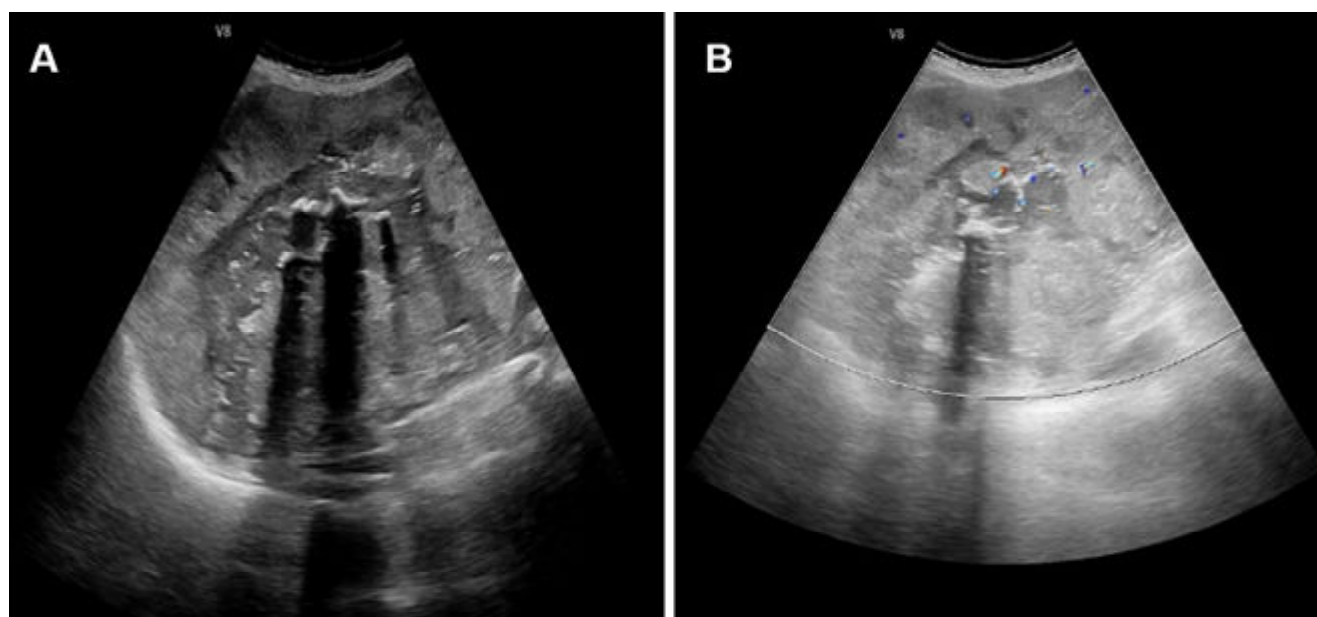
(A) large ill-defined heterogeneous lesion with the hyperechoic periphery and central hypoechoic area with multiple coarse calcifications completely occupying the right lobe of the liver; (B) mild vascularity on colour Doppler.
